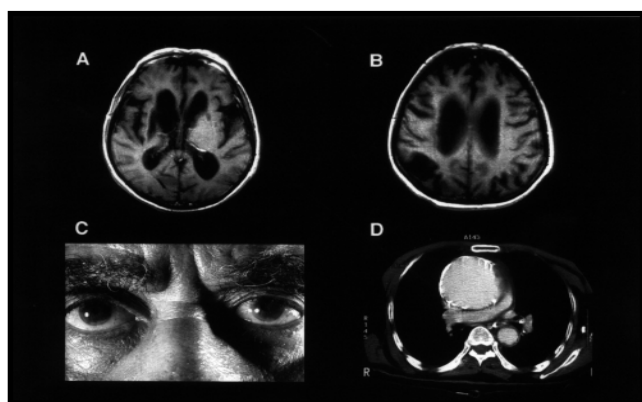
Patient 1 - A & B - MRI of the brain, T1 sequences in axial projection revealed prominent large lateral ventricles; the cortical sulci and sylvian fissures are moderately enlarged. Several lacunar infarcts involve the basal ganglia and corona radiata. There is a possibility of small cortical infarcts involving the posteroparietal convexity area. C - Right small pupil, non-reactive to light but reactive to accommodation. D - Very marked, aneurysmal widening of the ascending aorta with the largest diameter approximately 9-10 cm.
